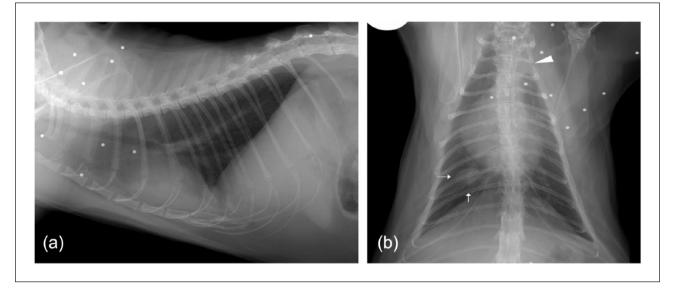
(a,b) Thoracic radiographs taken 8 weeks after discharge. A small amount of pleural fluid can be recognised on the left side (closed triangle in [b]). A nodule not previously seen is present in the right caudal lung hemithorax (arrows in [b])
